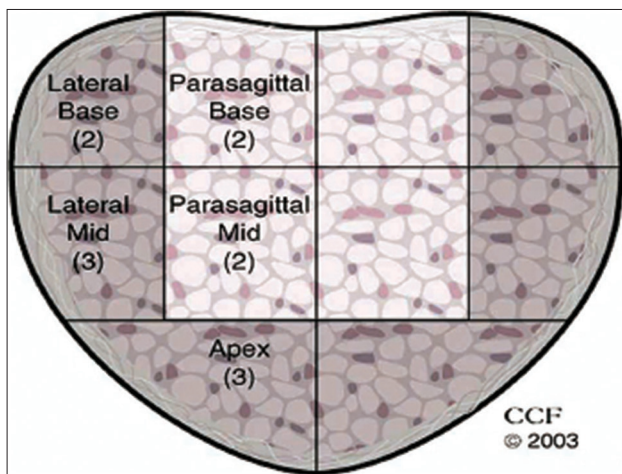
Template showing the location of cores obtained in 24-core needle transrectal ultrasound biopsy. In the 10-core biopsy protocol, one core was obtained from each of the same sectors
